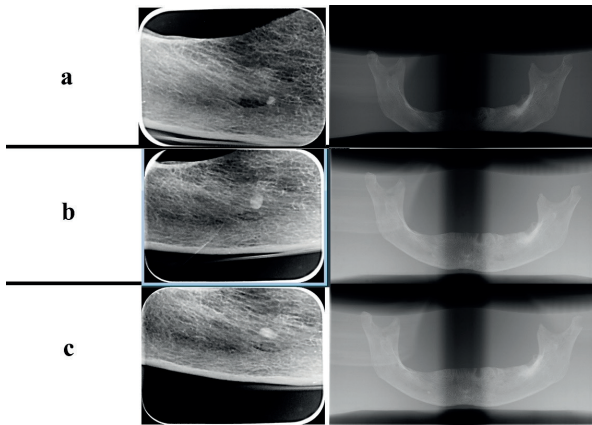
Periapical radiographs of the right third roots of different sizes; Panoramic radiography images of the left third roots of different sizes. a) Presence of 1 mm root (horizontal); b) Presence of 2 mm root (horizontal); c) Presence of 3 mm root (horizontal)
